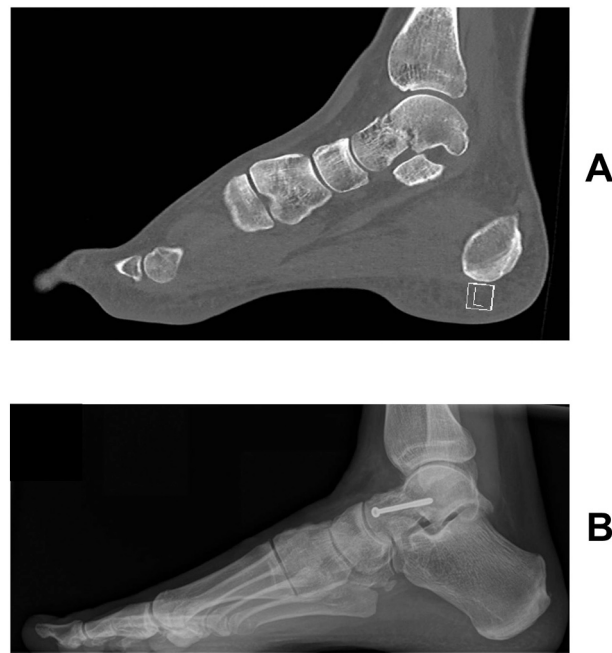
Panel A: Sagittal CT-view of right talar fracture.
